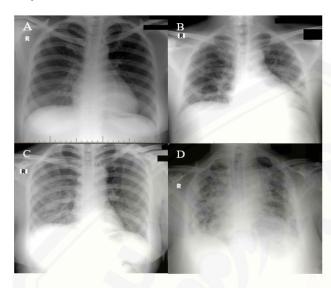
The severity of Chest Radiography Features. (A) 35-year-old female acquired seven days after symptom onset with a normal chest radiograph. (B) 45-year-old female acquired 14 days the symptom onset, showing ground-glass opacity on peripheral of the lungs and consolidation with mild severity. (C) 45-year-old male acquired nine days after the symptom onset, showing ground-glass opacity on both lung fields, with moderate severity. (D) 66-year-old female acquired 14 days after symptom onset, showing diffused extensive consolidation on both lung fields, with severe severity.
